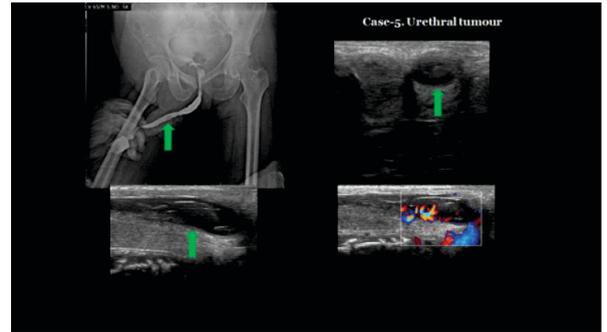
In a patient who presented with intermittent poor stream, recurrent hematuria and dysuria, RGU and SUG demonstrate a penile urethral tumour seen as a filling defect on RGU and a hypoechoic intraluminal mass with increased flow on colour Doppler interrogation.
